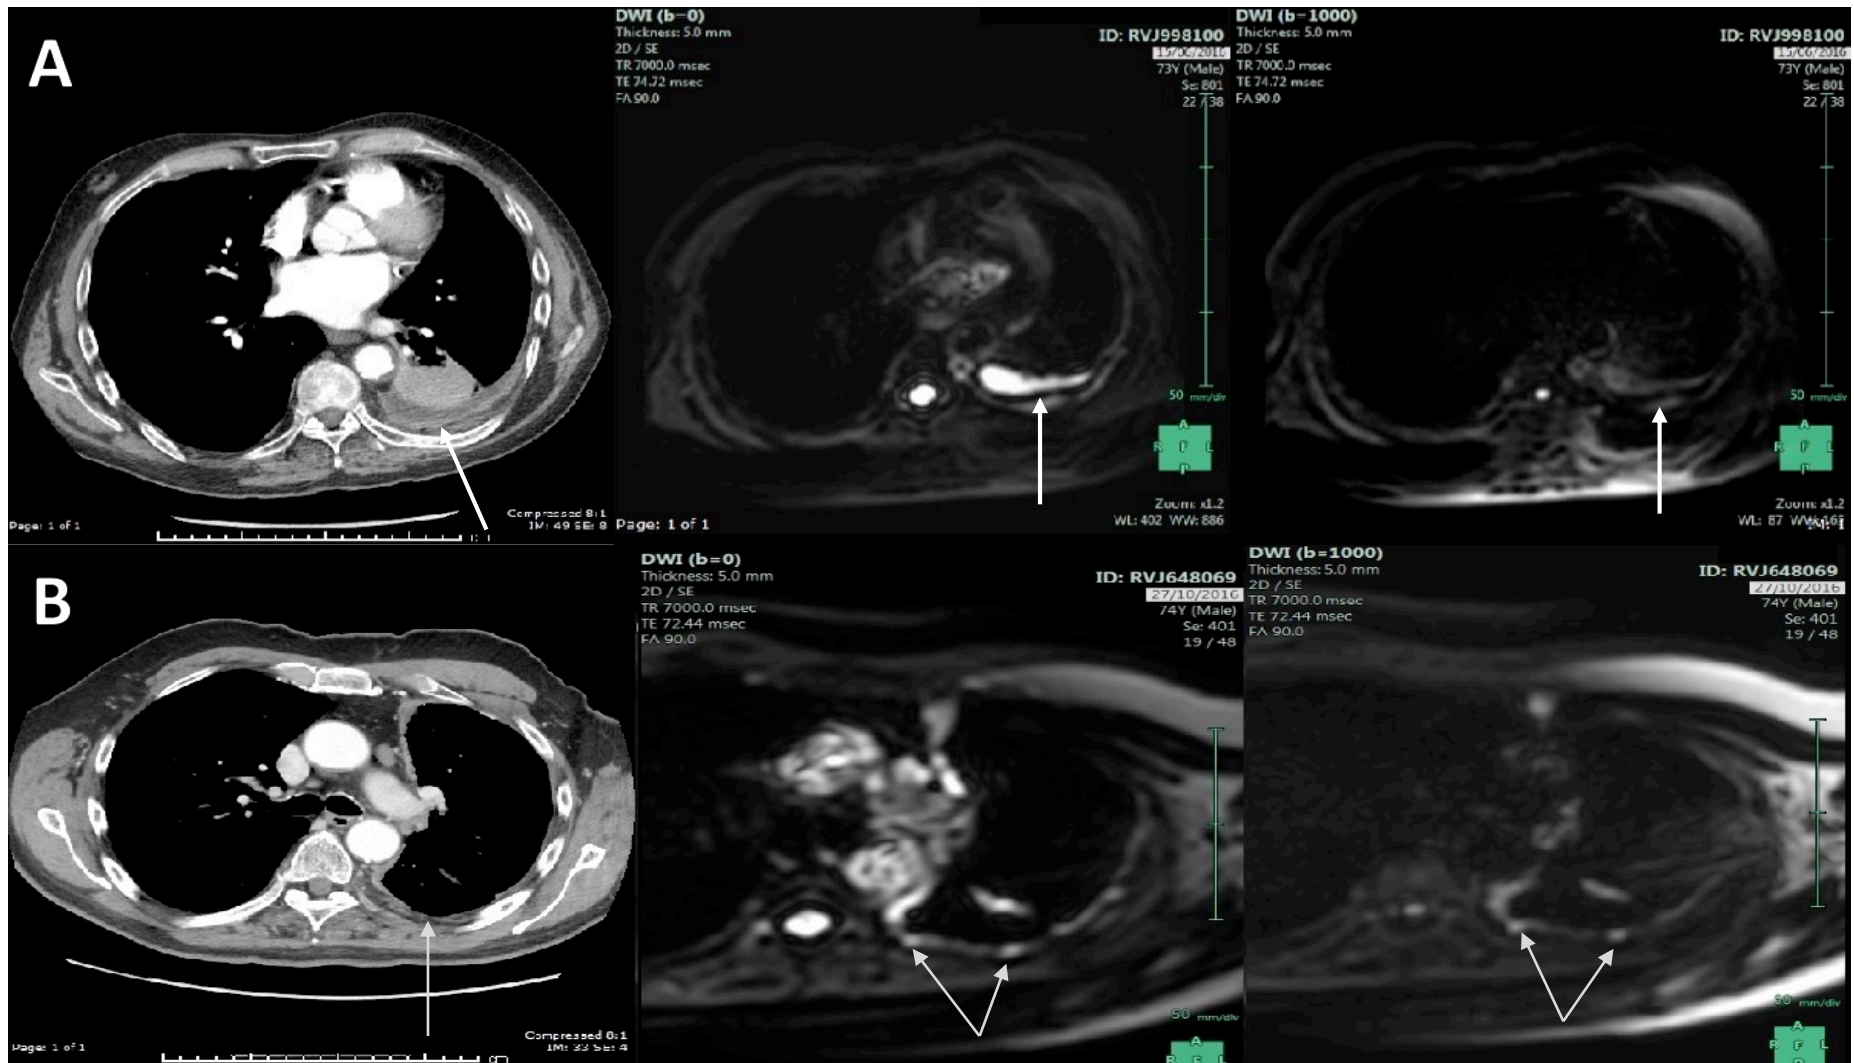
Axial CT image and corresponding DWI T2 weighted axial images on b=0 and b=1000 sequences showing pleural pointillism. Figure A shows benign pleural thickening on the right (arrow), with a small pleural effusion and folded lung above the effusion. On the corresponding b=1000 and b=0 images the pleura is seen as a dark band with no areas of hyper-intensity. Note fluid is bright on T2 weighted images hence the pleural effusion and spinal canal seen clearly on the middle image but less clearly on the b=1000 image. Figure B shows axial CT image of nodular pleural thickening which is seen as hyperintense areas on b=0 and b=1000 images.
